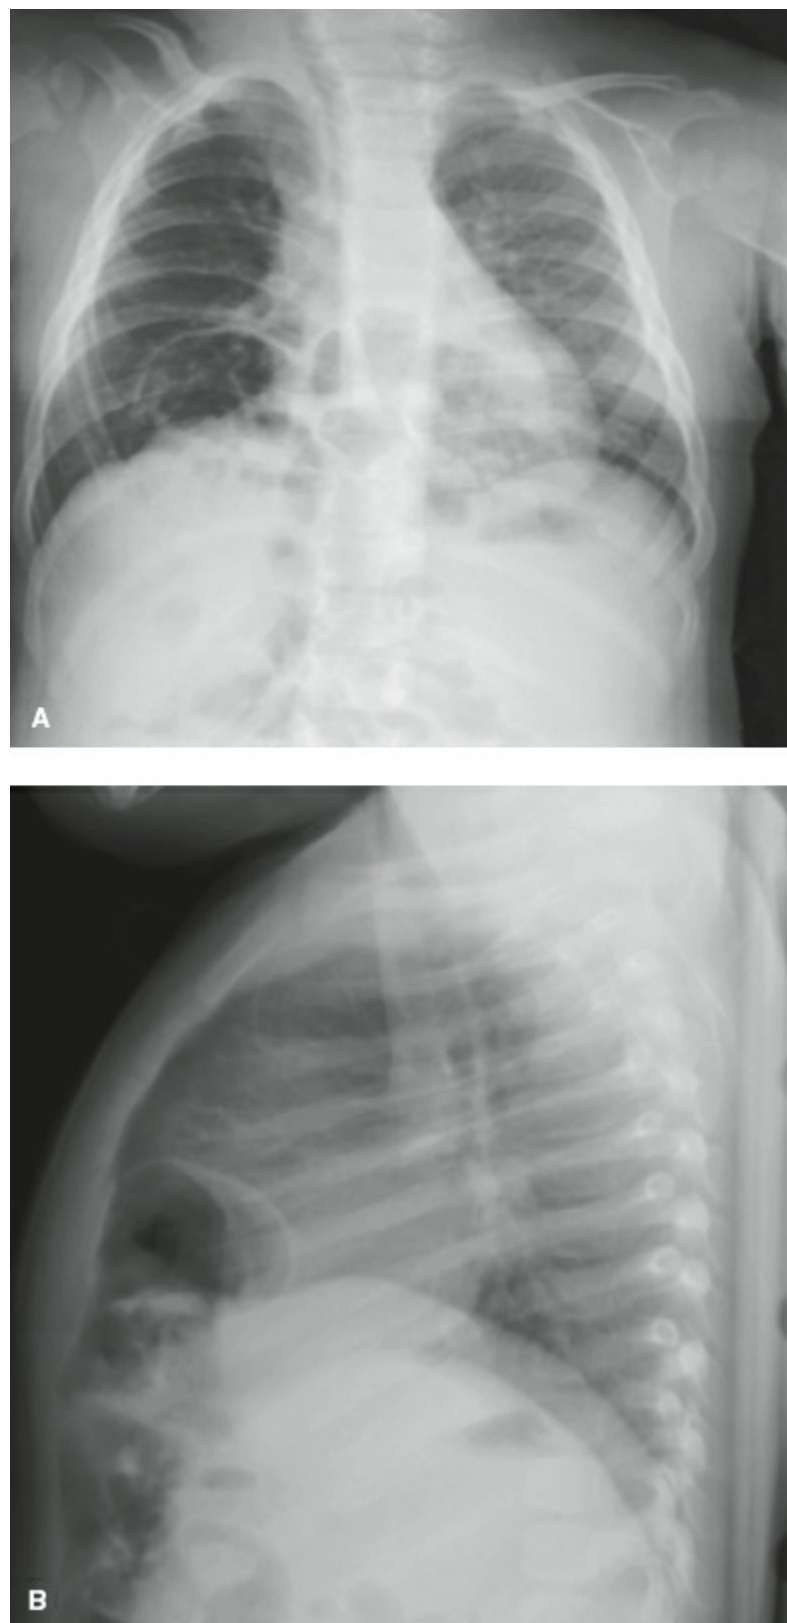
Morgagni hernia. (A) Anteroposterior and (B), lateral radiographs of patient with Morgagni hernia.
